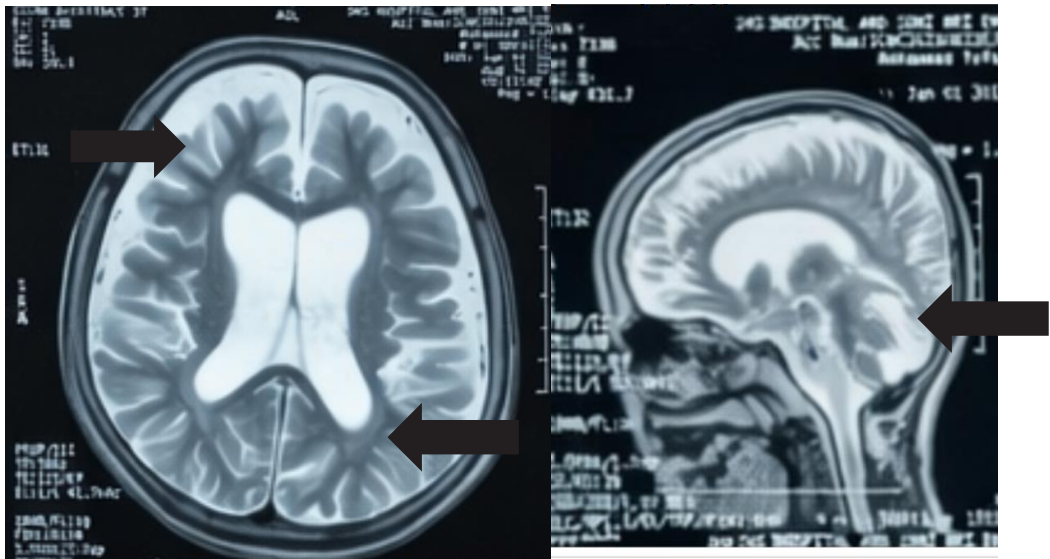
MRI Brain scan suggestive of hyperintensities adjacent to the bilateral posterior horns of the lateral ventricles on T2-weighted images and extensive cerebral and cerebellar degeneration.
